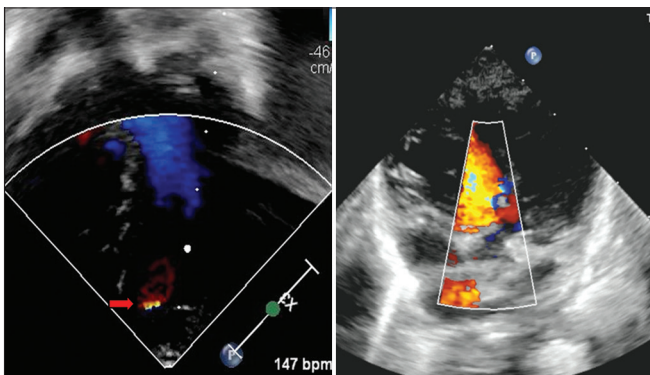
Echocardiography showing left ventricular apical diverticulum (arrow) and large perimembranous ventricular septal defect
